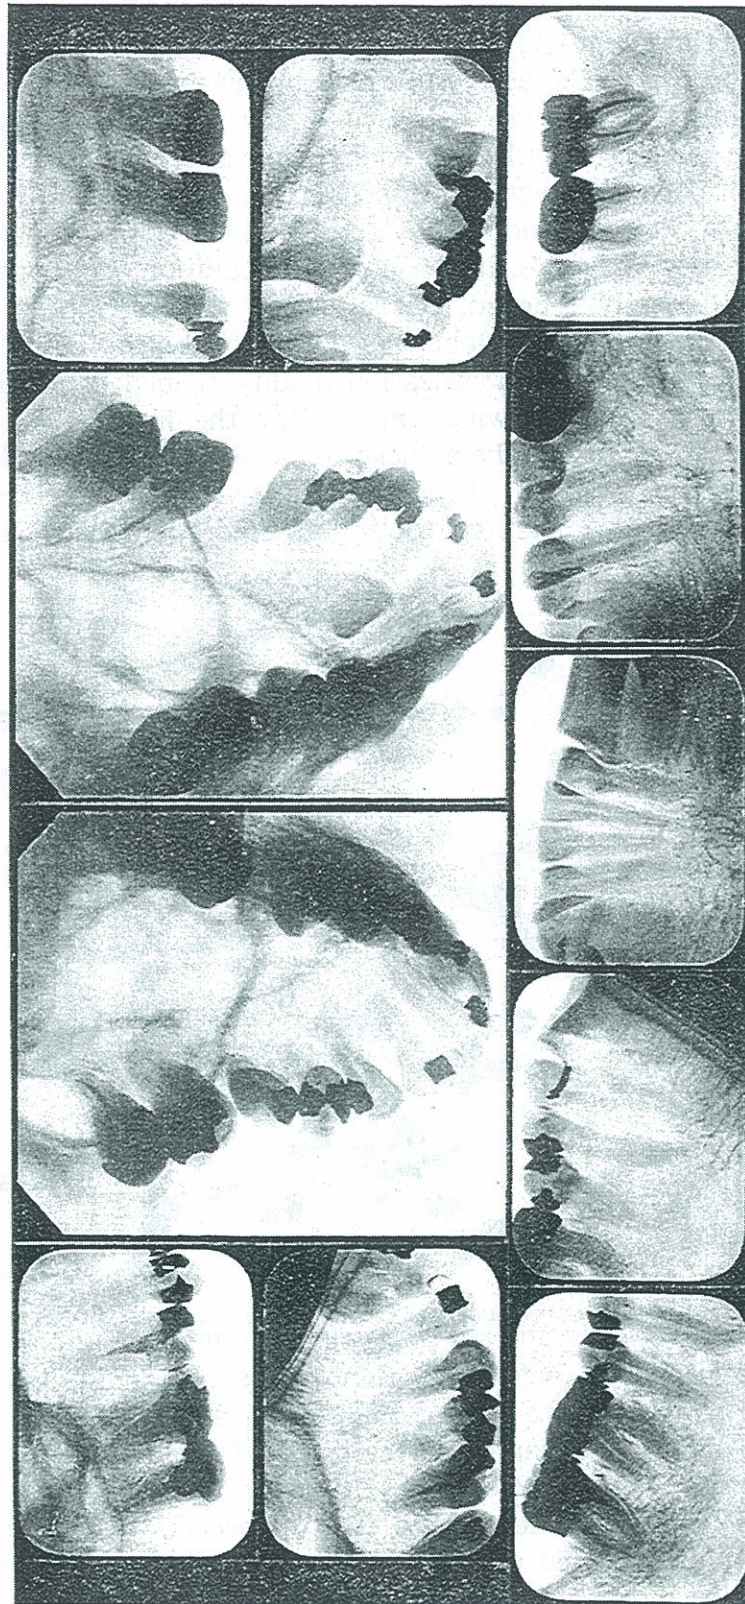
ROENTGENOGRAPHIC APPEARANCE OF TEETH OF CASE 1335 WITH HISTORY OF SEVERE HEART INVOLVEMENT.
